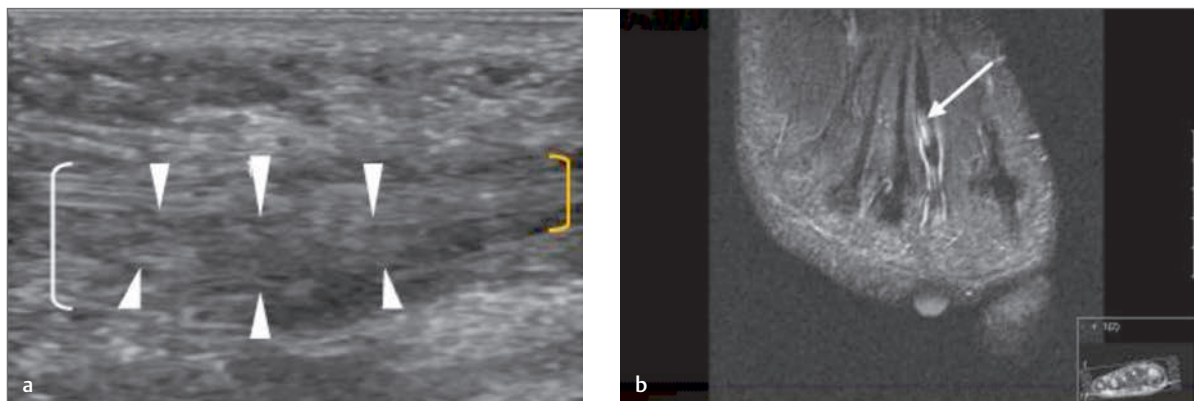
(a) Longitudinal image of the plantar aspect of the second toe and associated tendon of flexor digitorum longus. The image demonstrates thickening and a loss of normal fibrillar pattern within the substance of the tendon in keeping with an intrasubstance tear (white arrowheads). (b) MRI image (T2 axial) of the same area as in part (a). There is a high signal around the tendon of flexor digitorum longus at the second metatarsal. There is a diffuse thickening of the tendon with high signal (white arrow). White arrow, high signal within the tendon of flexor digitorum longus at the second metatarsal; white bracket, thickened tendon; yellow bracket, normal tendon diameter.
